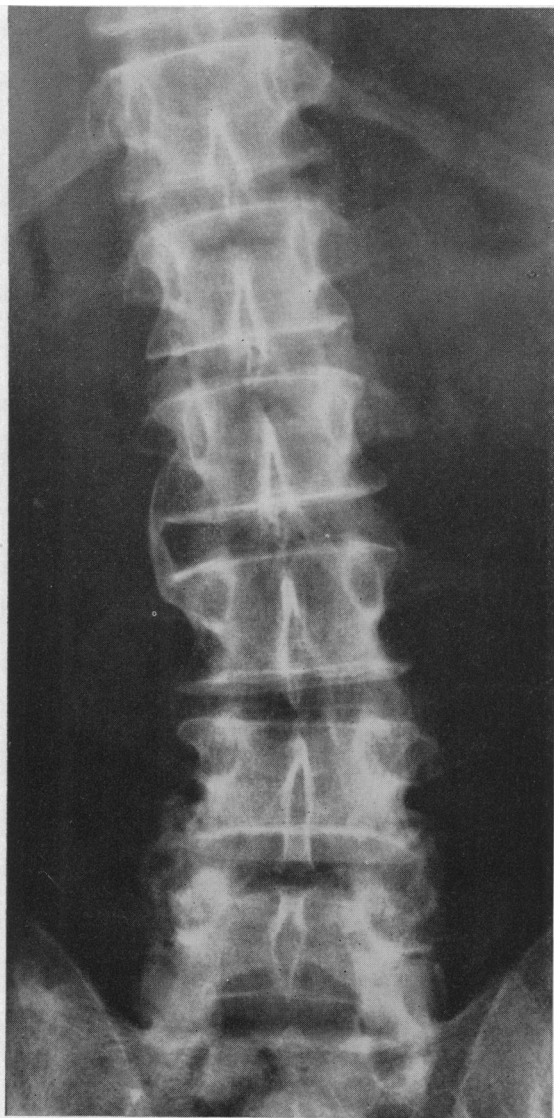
Case 2. X-ray of spine (Feb. 1956), showing bridging L.2, 3 and early bridging T.12, L.1, L.2. Some sclerosis of apophyseal joints.
